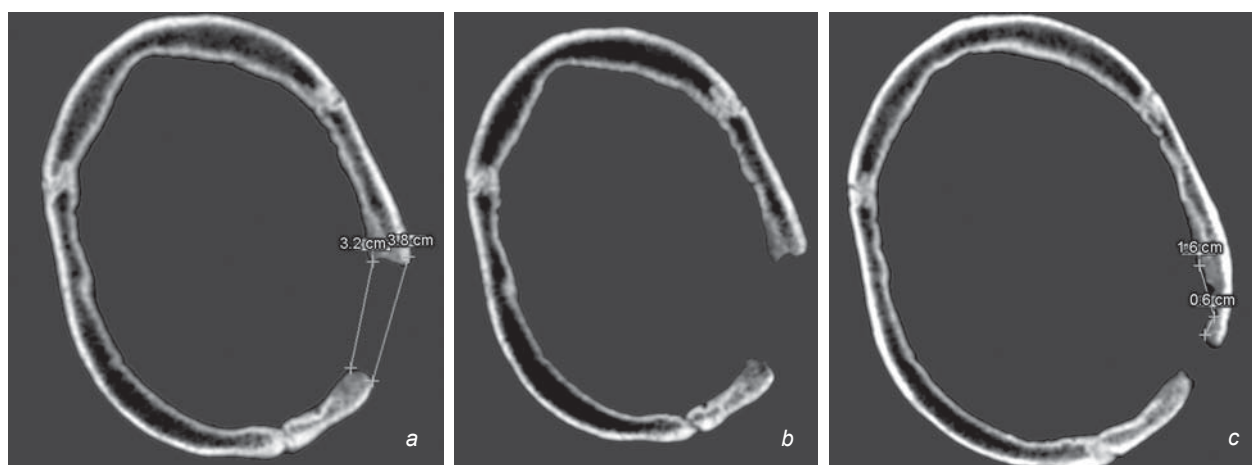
Computed tomography images of the skull: the slices demonstrating maximum dimensions of the trepanation defect (a), manifestations of bone neoplasm along its edges (b), and signs of bone usurpation (c).
